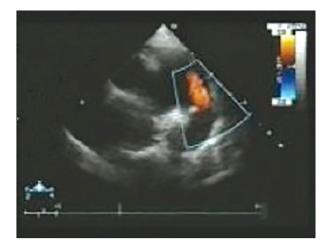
2D Echocardiography-colour Doppler image showing a large non-restrictive patent ductus arteriosus shunting predominantly left to right
